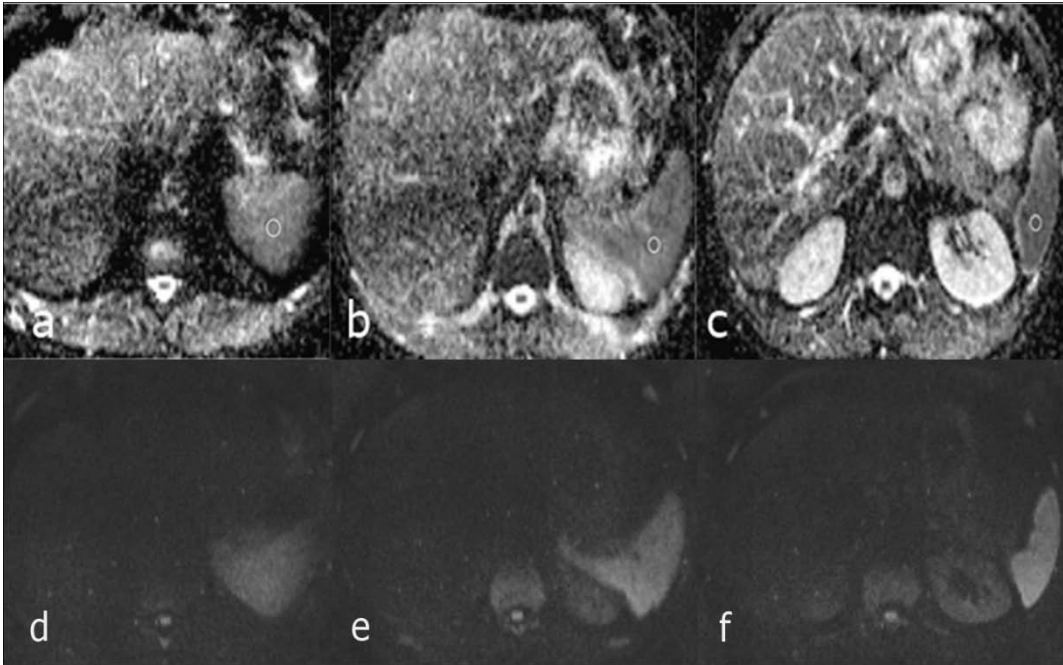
(a–c) MRI upper abdominal ADC mapping images of cirrhotic patient with stage F3 fibrosis. (d–f) DWI images at same sections.
